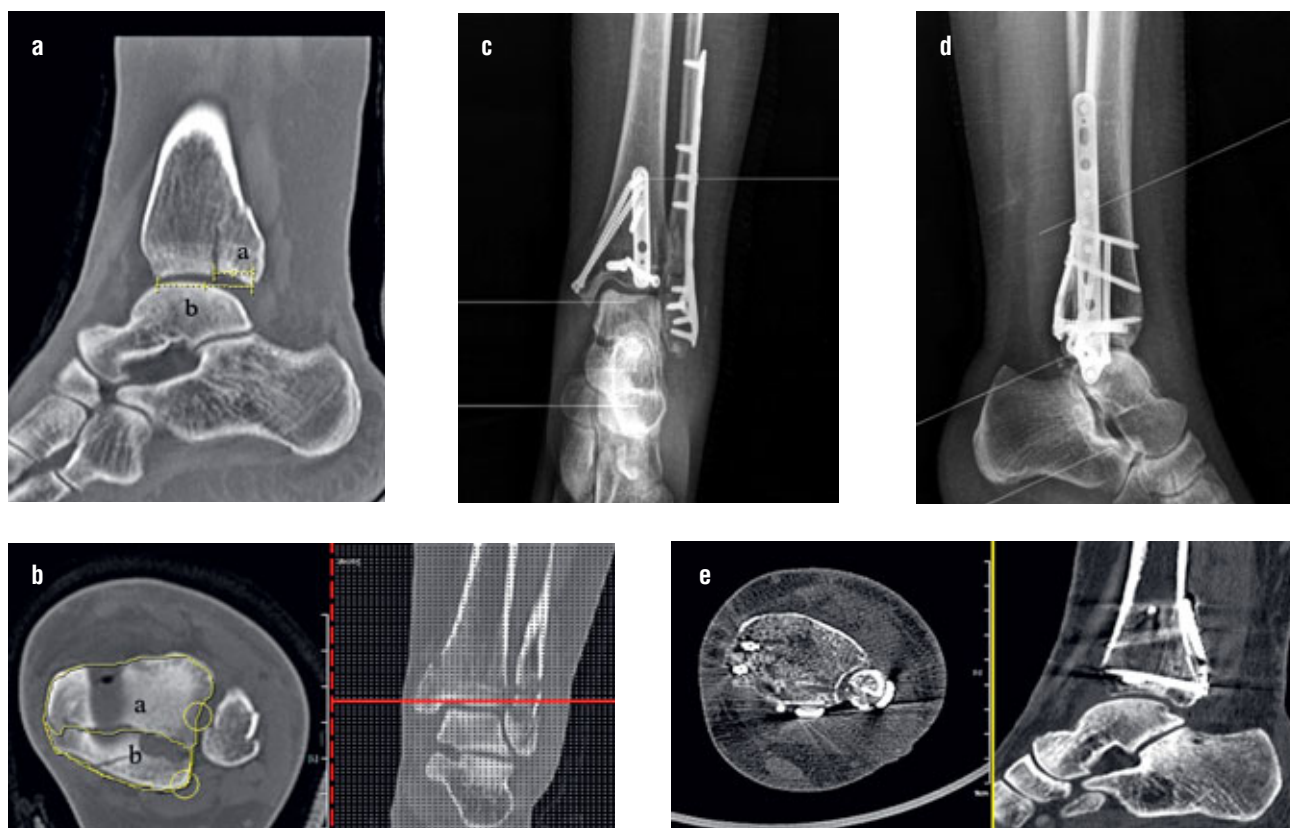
The posterior fragment was fixed by posterior open approach: a – percentage of the posterior fragment: $a/b \times 100$, b – percentage of the posterior fragment: $b/a+b \times 100$, c, d – AP and lateral X-rays, e – CT scan, postoperatively.
